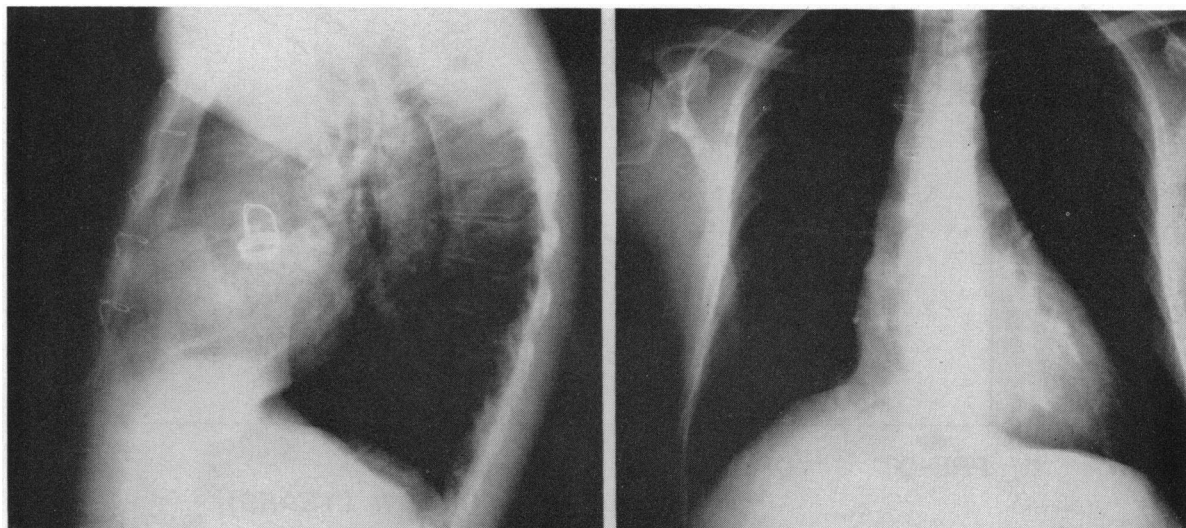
Posterior-anterior and lateral chest roentgenogram, two months after operation, in a patient with calcific aortic stenosis.
